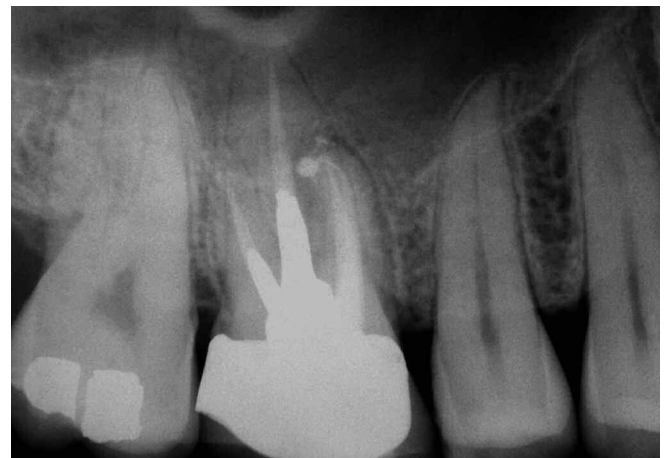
A 2-year recall radiograph demonstrates excellent healing associated with the MB root.
